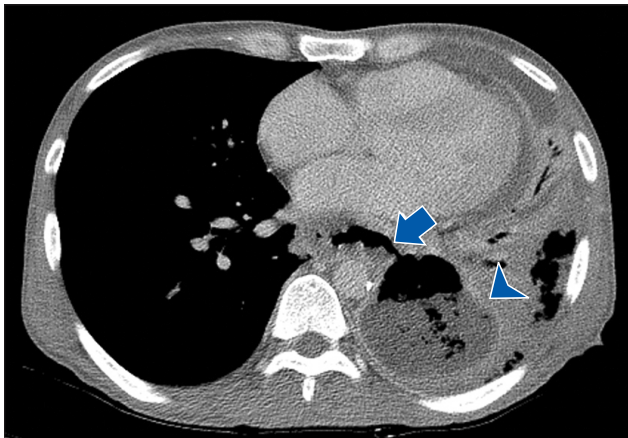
Computed tomography shows a pneumonic infiltration and abscess in the left lower lobes. The arrow indicates the perforation of esophagus and communication to the lung, and the arrowhead indicates a lung abscess in the left lower lobe.
